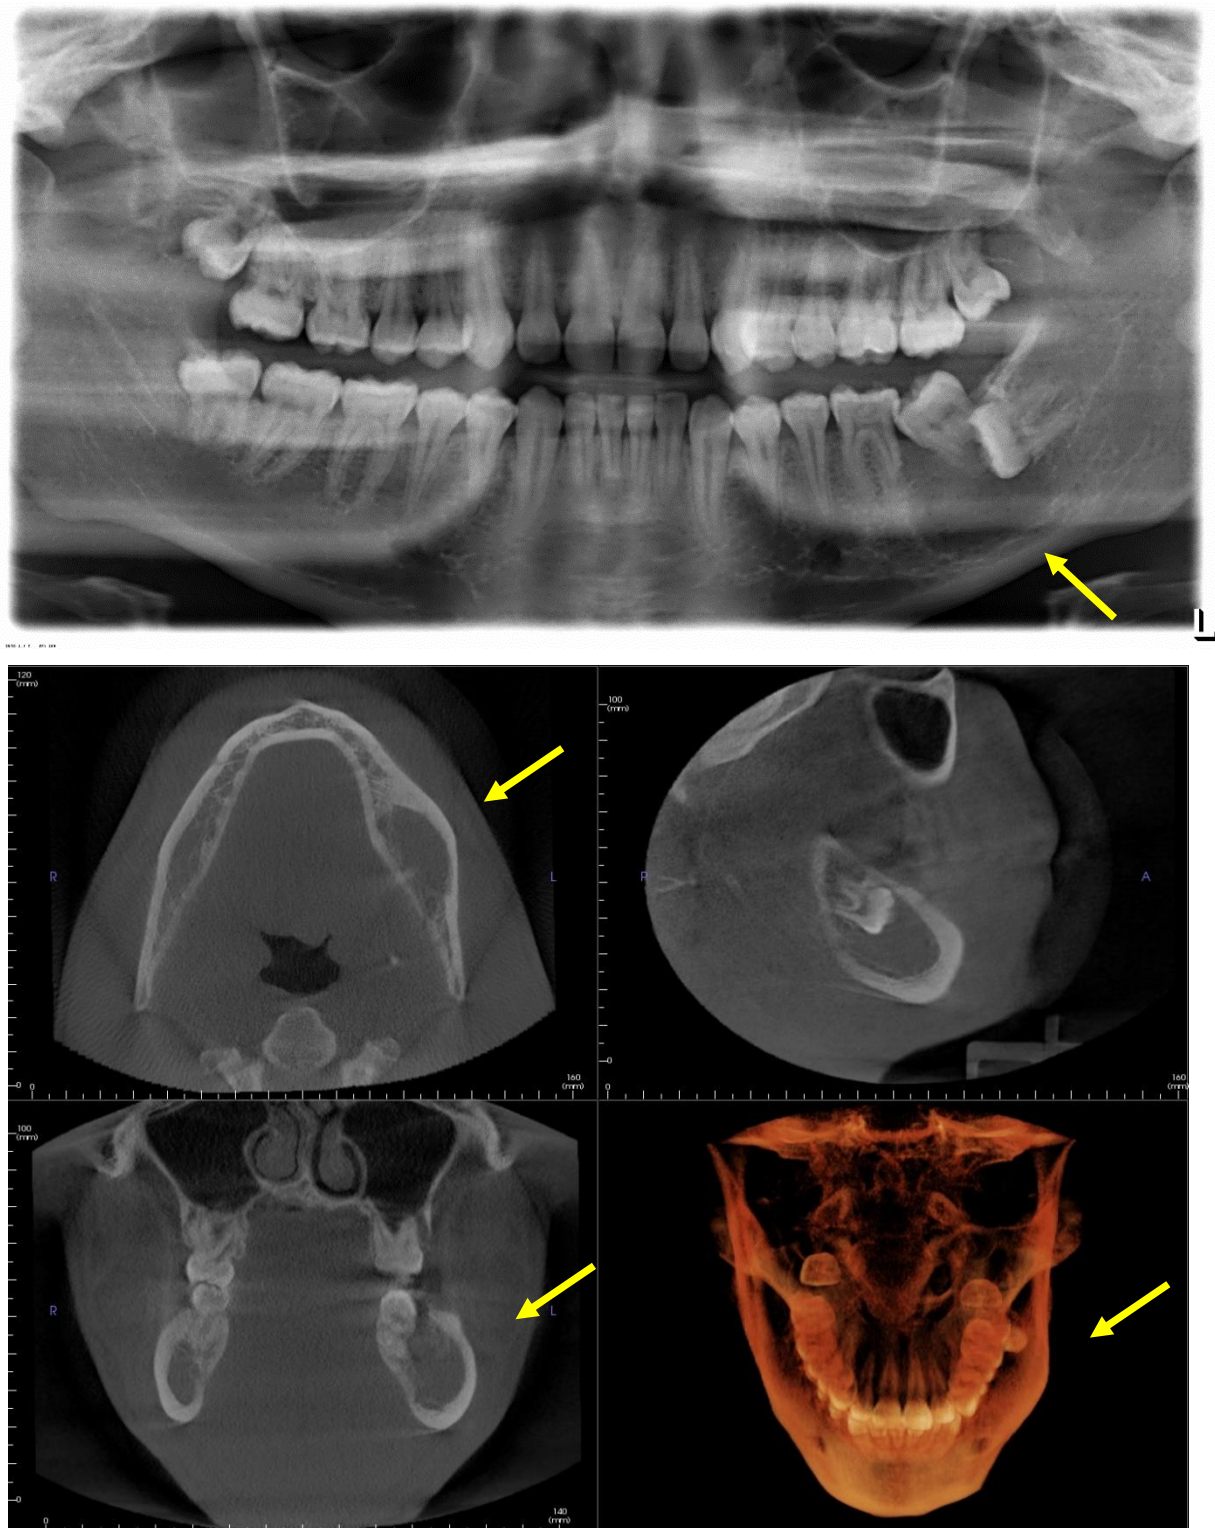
Example of CBCT demonstrating displacement of IAC not seen on PAN
